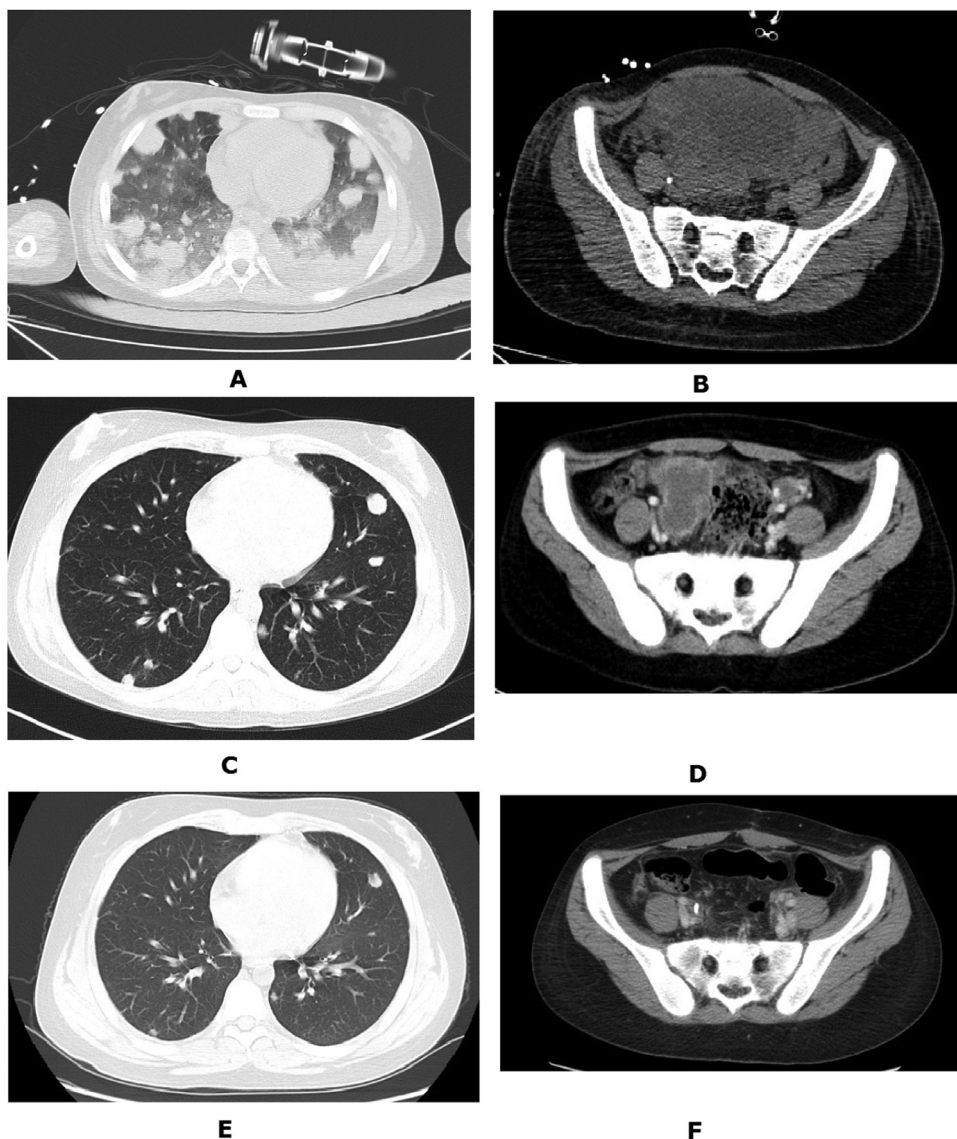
Imaging changes in the thoracic and pelvic cavities via computed tomography (CT) during the treatment period. (A and B) were taken on the second day (October 27, 2018) of first cycle of actinomycin D and etoposide (AE). (C and D) were taken on December 17, 2018, after 2 cycles of AE and 2 cycles of chemotherapy with transvenous etoposide, methotrexate and actinomycin D/cyclophosphamide and vincristine (EMA/CO) and intrathecal methotrexate (MTX). (E and F) were taken on February 6, 2019, 1 month after the unilateral salpingo-oophorectomy surgery. (A) Chest CT scan showed multiple nodules surrounded by areas of ground-glass opacity, bulky lymphadenopathy in the hilum and mediastinum, multiple fibrous stripes and bilateral pleural effusion and atelectasis. (B) Pelvic CT scan showed an irregular bulky mass with a 10 cm diameter. (C and E) Chest CT scan showed persistent shrunken thoracic nodules and bulky lymphadenopathy compared with (A). Bilateral pleural effusion and atelectasis disappeared. (D) Pelvic CT scan showed a significantly shrunken mass compared with (B). (F) Pelvic CT showed the disappearance of the bulky mass in (B) and (D).
